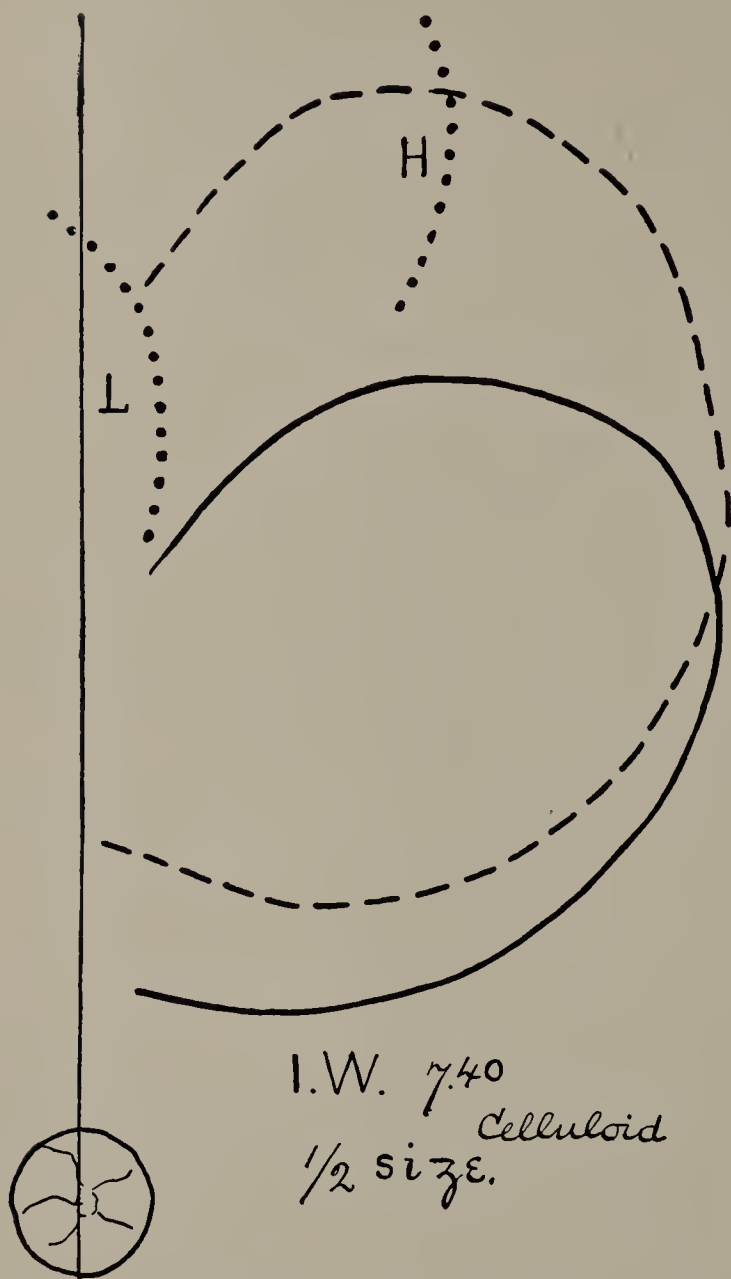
James W. Cut of X-ray tracing made on celluloid. 7.40 P.M. Broken line shows size and position of stomach in expiration; full line, in deep inspiration.
